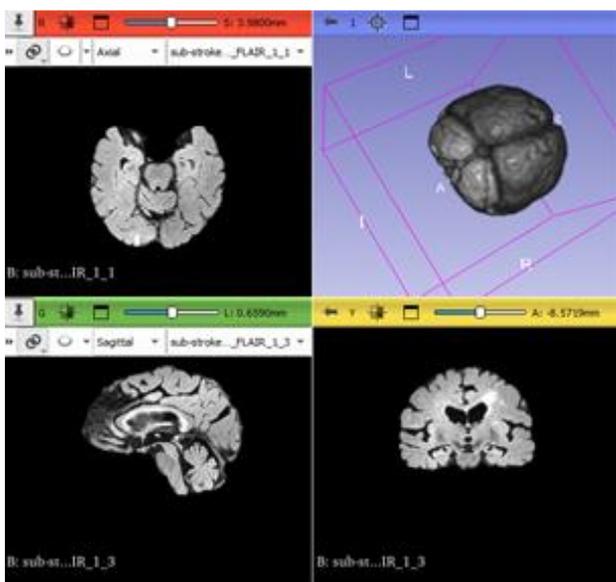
FLAIR – cross-sectional views (Axial, Coronal and Sagittal) + 3D Rendering
